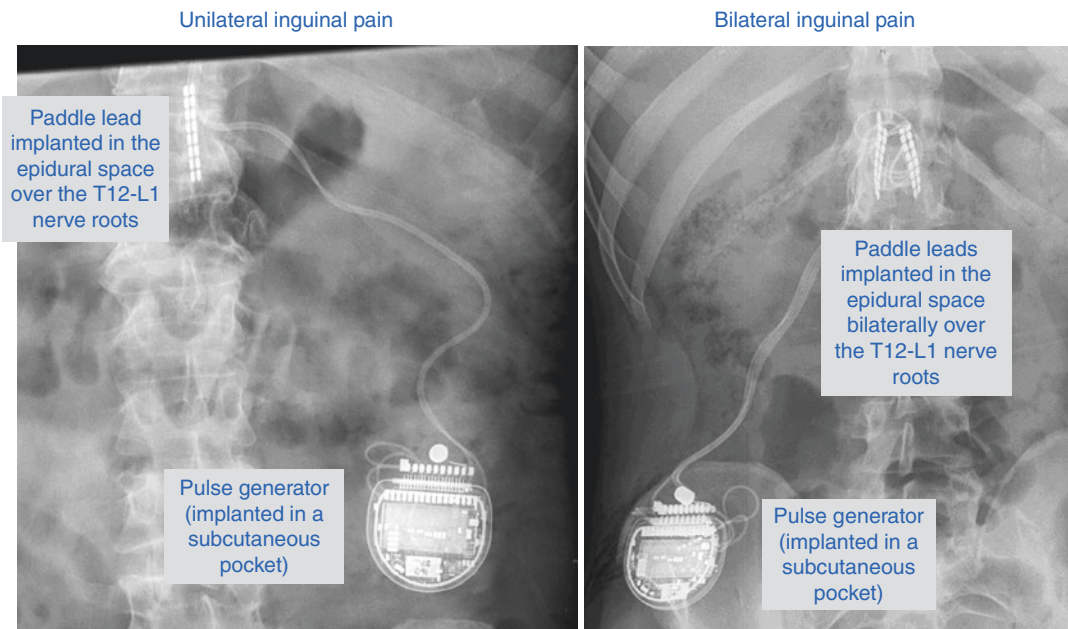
X-rays of implanted T12-L1 dorsal nerve root stimulation systems for inguinal pain
